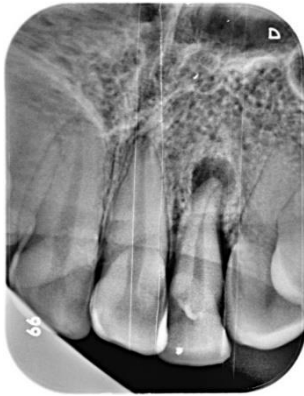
Preoperative intraoral radiograph a periapical radiolucency related to 22
